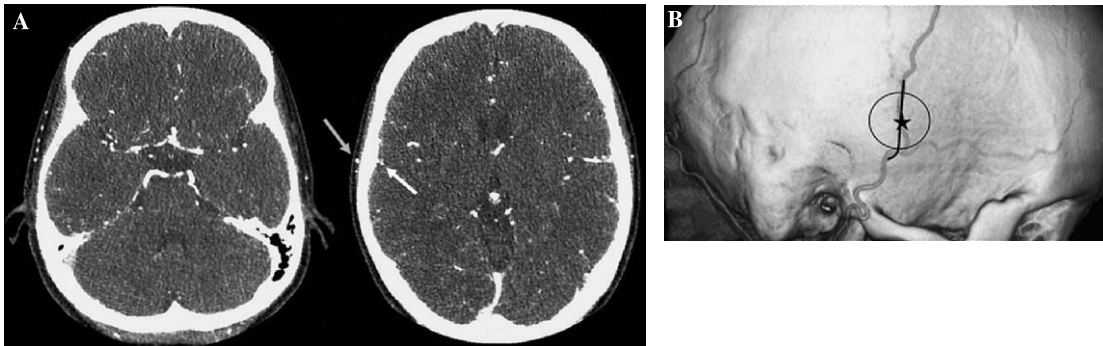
(A) Original image of 3D CTA demonstrates a parietal branch of STA within the scalp and a cortical artery on the brain surface. The most suitable segment of both the artery provided as donor (*gray arrow*) and recipient arteries (*white arrow*) for EC-IC bypass. The distance between the afore-mentioned segment of donor artery (*gray arrow*) and the superior border of the helix (*arrowhead*) were calculated. (B) Image of craniotomy superimposed on the skull image of preoperative 3D CTA, *asterisk* indicates the afore-mentioned segment of donor artery (center of craniotomy)
